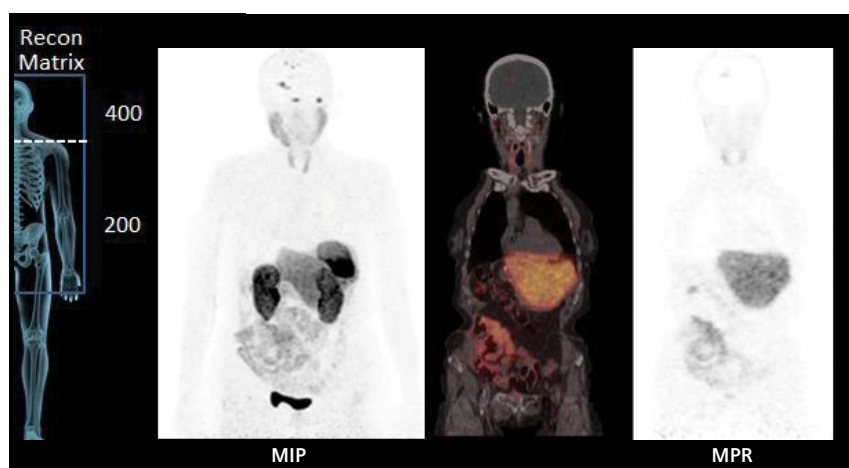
Whole-body 200 x 200 matrix reconstructions of ^{68}Ga DOTATATE PET/CT and fused images show multiple focal uptakes in the brain, which suggests metastases.
